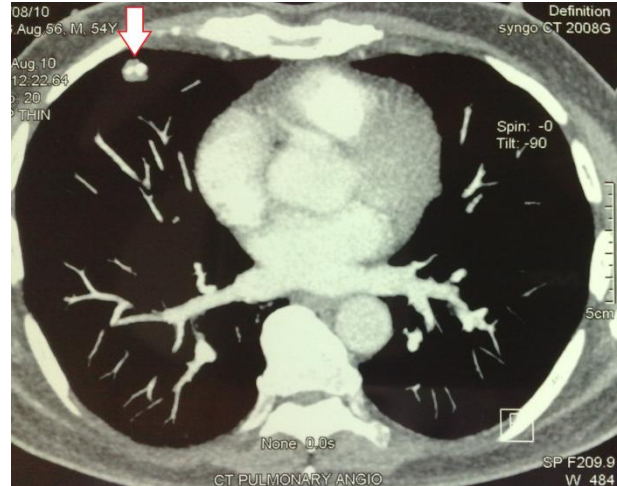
CT scan showing the hamartoma in the right middle lobe with the characteristic "pop-corn" appearance of the central calcification.
